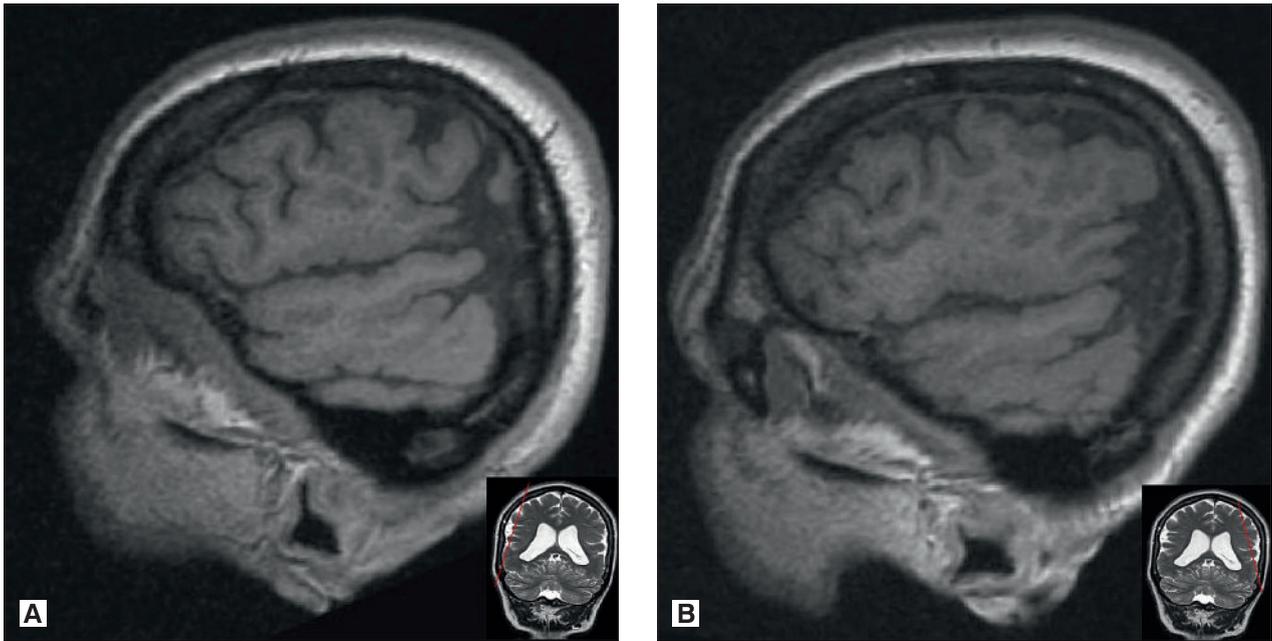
Brain MRI, T1-weighted, right (A) and left (B) sagittal. Primary and secondary sulci of cortex are abnormal. Dorsal parts of lateral sulci turn into significantly enlarged subarachnoidal space in parietal lobes, perisylvian polymicrogyria is present.
